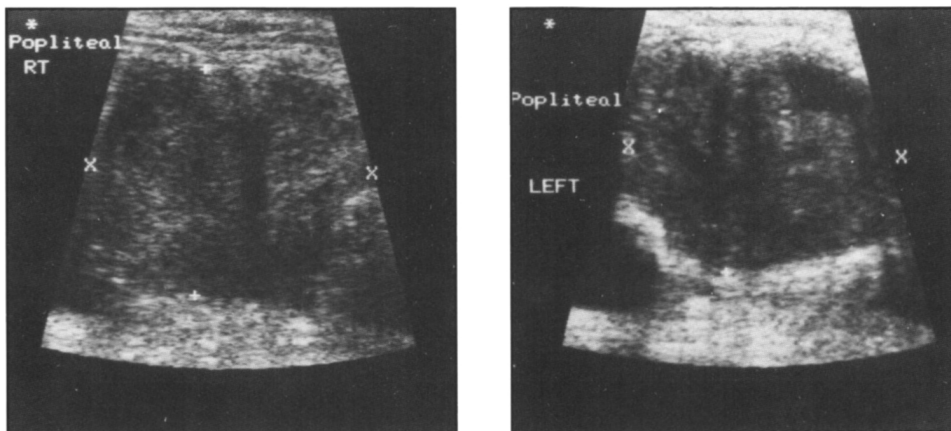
Ultrasound studies of the popliteal fossae to show large areas of reduced density with inner areas of variable increased density, suggesting popliteal aneurysms containing clots and calcifications.
